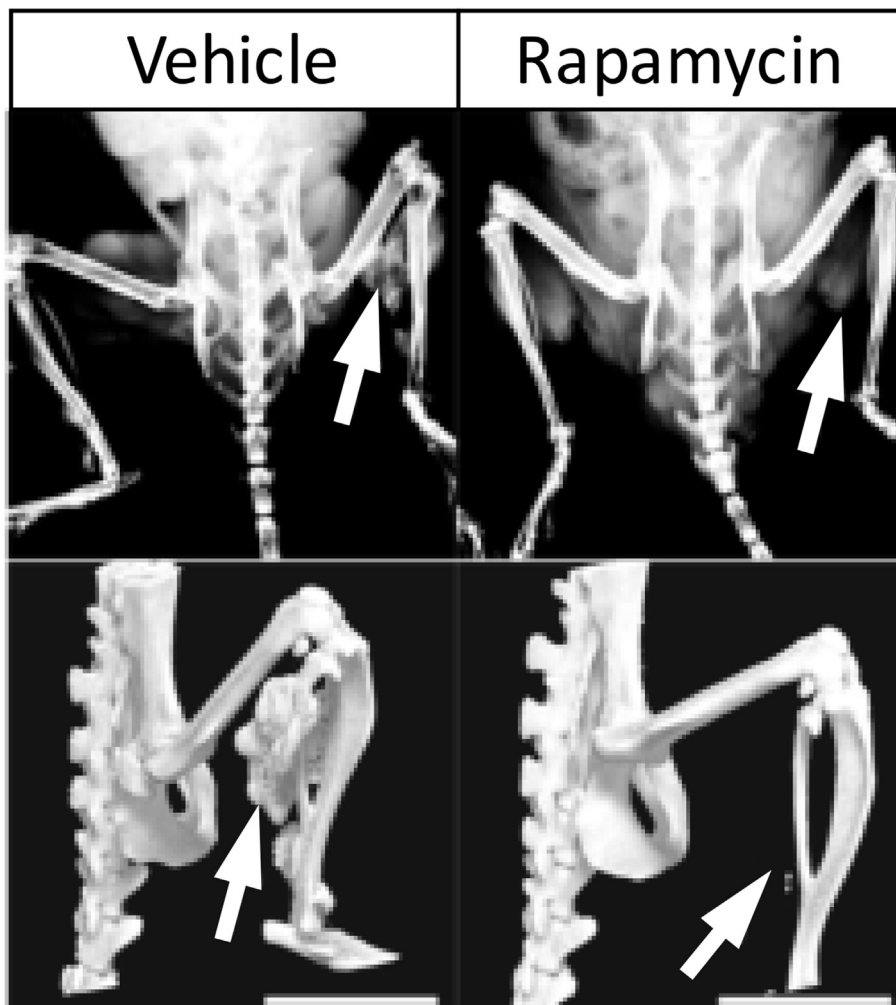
Rapamycin suppresses ectopic bone formation. X-ray (upper row) and μ CT (bottom row) images. Administration of rapamycin suppressed activin A-triggered ectopic bone derived from FOP-MSCs. White arrows show the transplanted area. This figure has been modified from Hino et al. [77].
